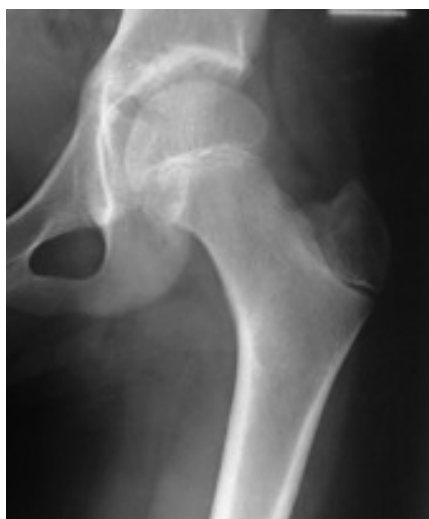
X-ray taken after implant removal.
